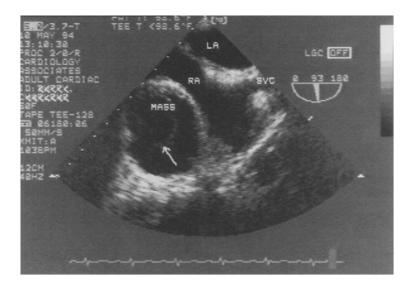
Transesophageal echocardiogram with multiplane probe at 93 degrees. Mass is seen to cause partial compression of right atrium (RA). Somewhat vague, echodense curvilinear target is seen within mass, possibly representing trabeculum within hemangioma. LA, Left atrium; SVC, superior vena cava.
